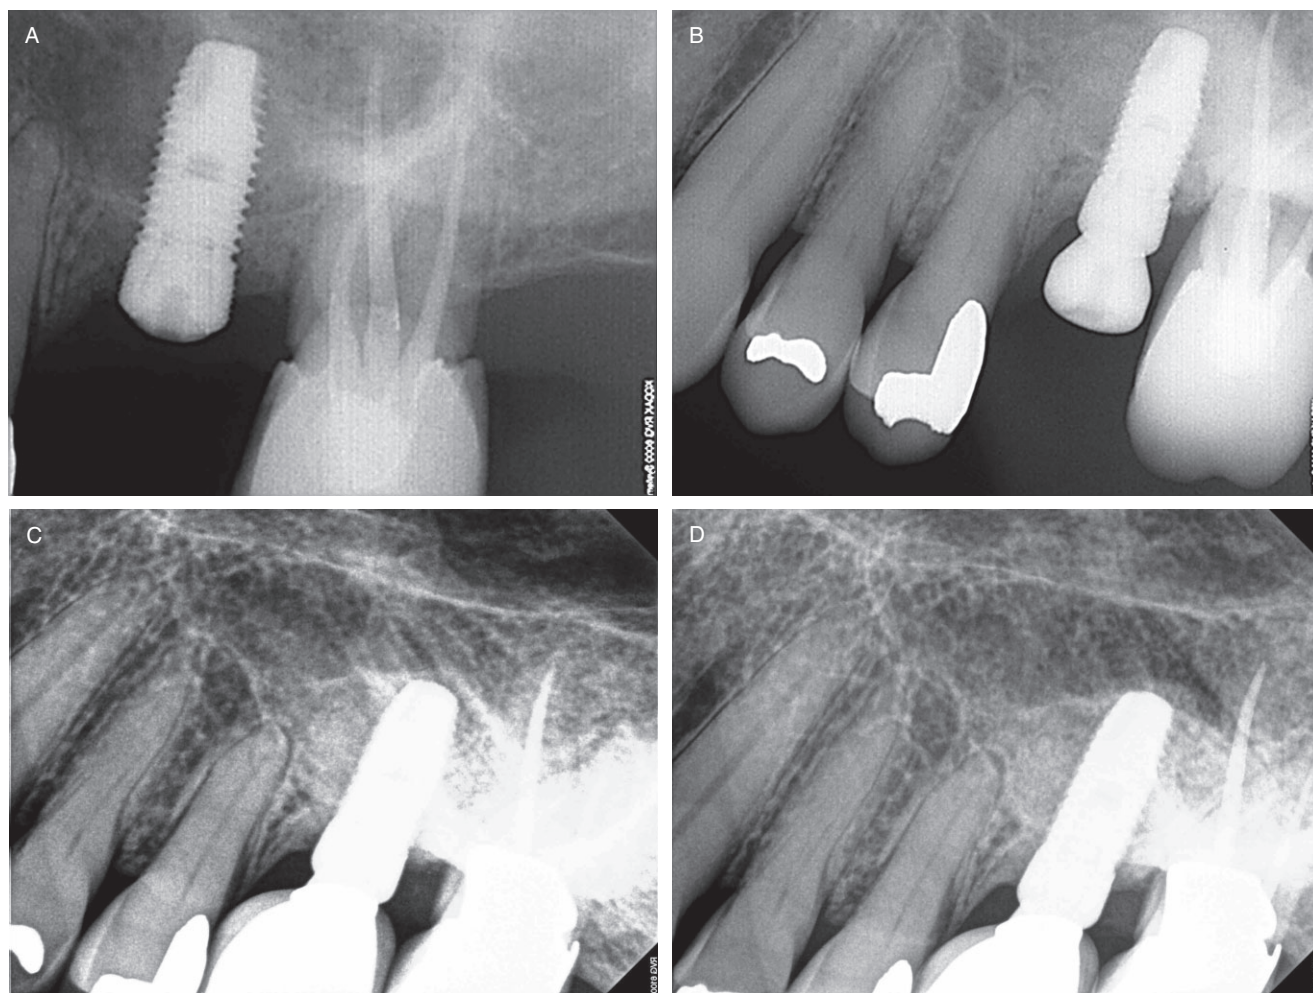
A, Periapical radiograph taken at the time of sinus grafting using autogenous bone from intraoral source and simultaneous implant placement. Note the height of the crestal alveolar bone. B, Periapical radiograph taken at the time of abutment connection. Note the height of the crestal alveolar bone. C, Periapical radiograph taken at the time of crown insertion. D, Periapical radiograph taken at 3 years after implant placement. Note new bone formation within the maxillary sinus surrounding the implant body.
